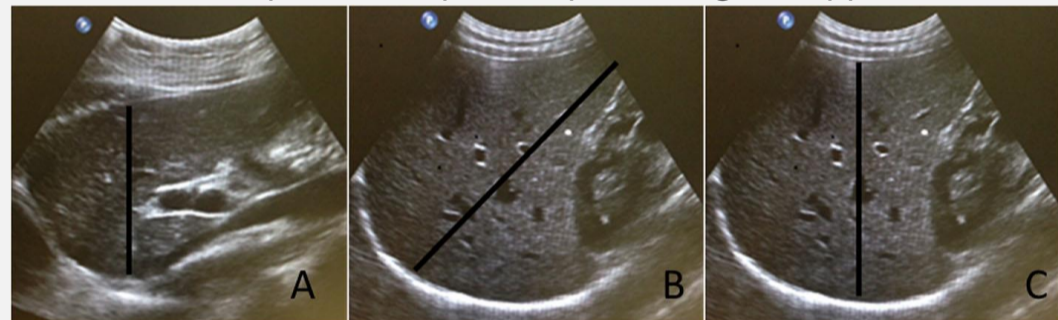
Liver Size Ultrasound measurement using Liver volume⁴ (cm³) = 343.71 + [0.84 × ABC], where A- Anterior to Posterior measurement of Left lobe of liver (probe placed longitudinally at where xiphisternum); B- Dome of liver to tip of Right liver (probe placed longitudinally at right midclavicular line); C- Anterior to posterior measurement of Right lobe of liver (probe placed longitudinally at right midclavicular line).
